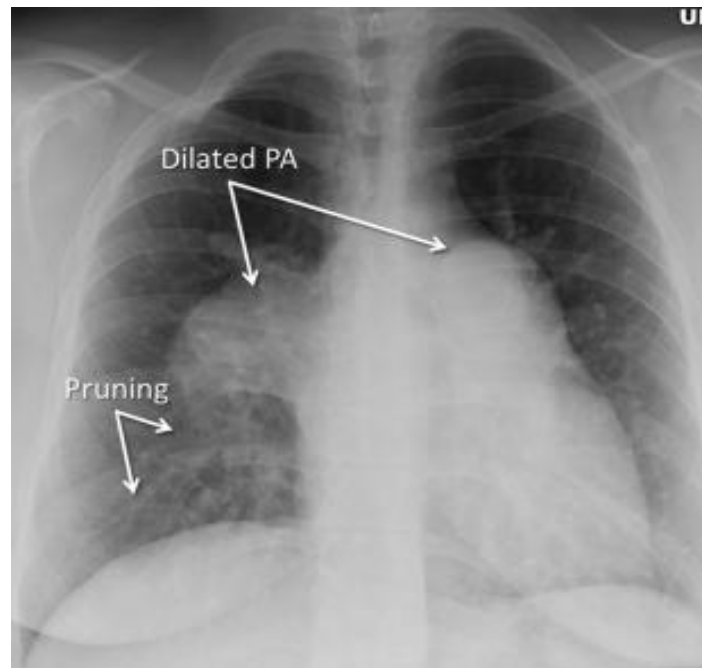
Chest X-ray for Pulmonary Hypertension (15)
